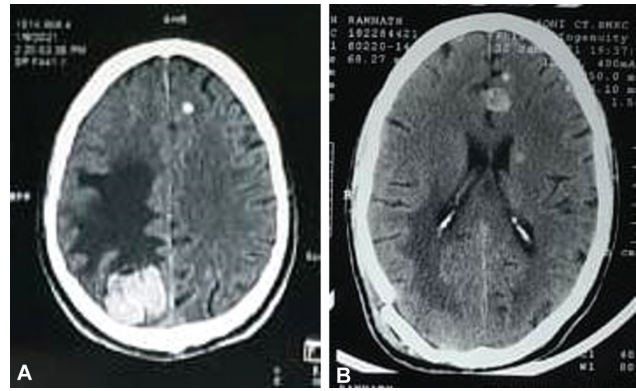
(A) Axial preoperative noncontrast computed tomography (CT) of the head shows a hyperdense mass lesion in the right parieto-occipital region with significant surrounding perilesional edema with a left frontal small hyperdense lesion. (B) Postoperative CT of the head shows complete resection of the right parieto-occipital lesion.
